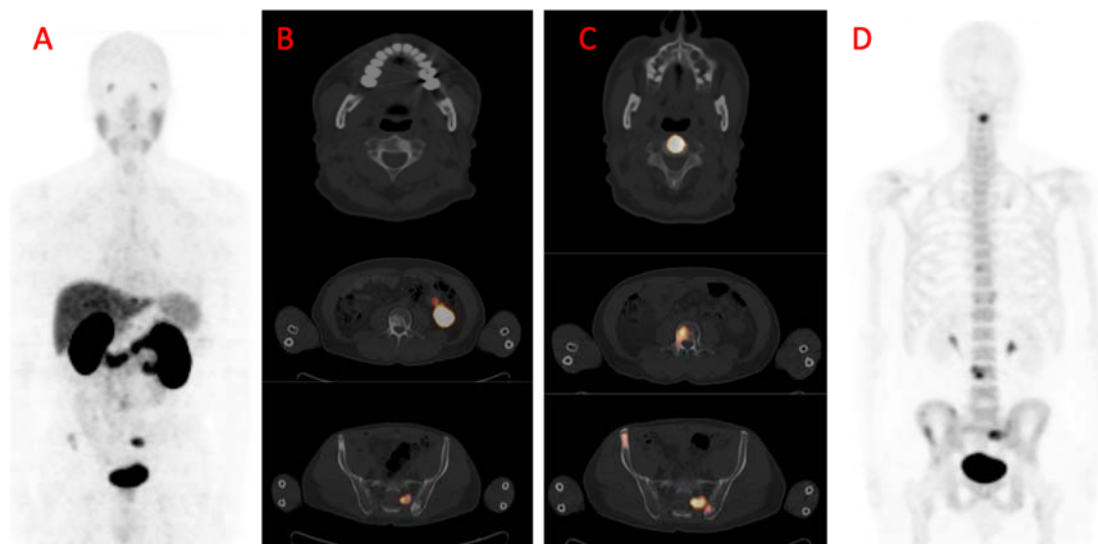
A 55-year-old male with metastatic prostate carcinoma, Gleason score of 4+5, PSA of 48.58 ng/mL. His prior treatment included androgen deprivation therapy and six cycles of [¹⁷⁷Lu]Lu-PSMA-617 therapy, followed by six cycles of [²²⁵Ac]Ac-PSMA-617 therapy. MIP image (A) and multiple fused axial PET/CT sections (B) of [⁶⁸Ga]Ga-PSMA-11 PET/CT show minimal skeletal metastases. Conversely, multiple fused axial PET/CT images (C) and MIP image (D) of [⁶⁸Ga]Ga-NODAGA^{ZOL} PET/CT show more extensive skeletal metastases.
